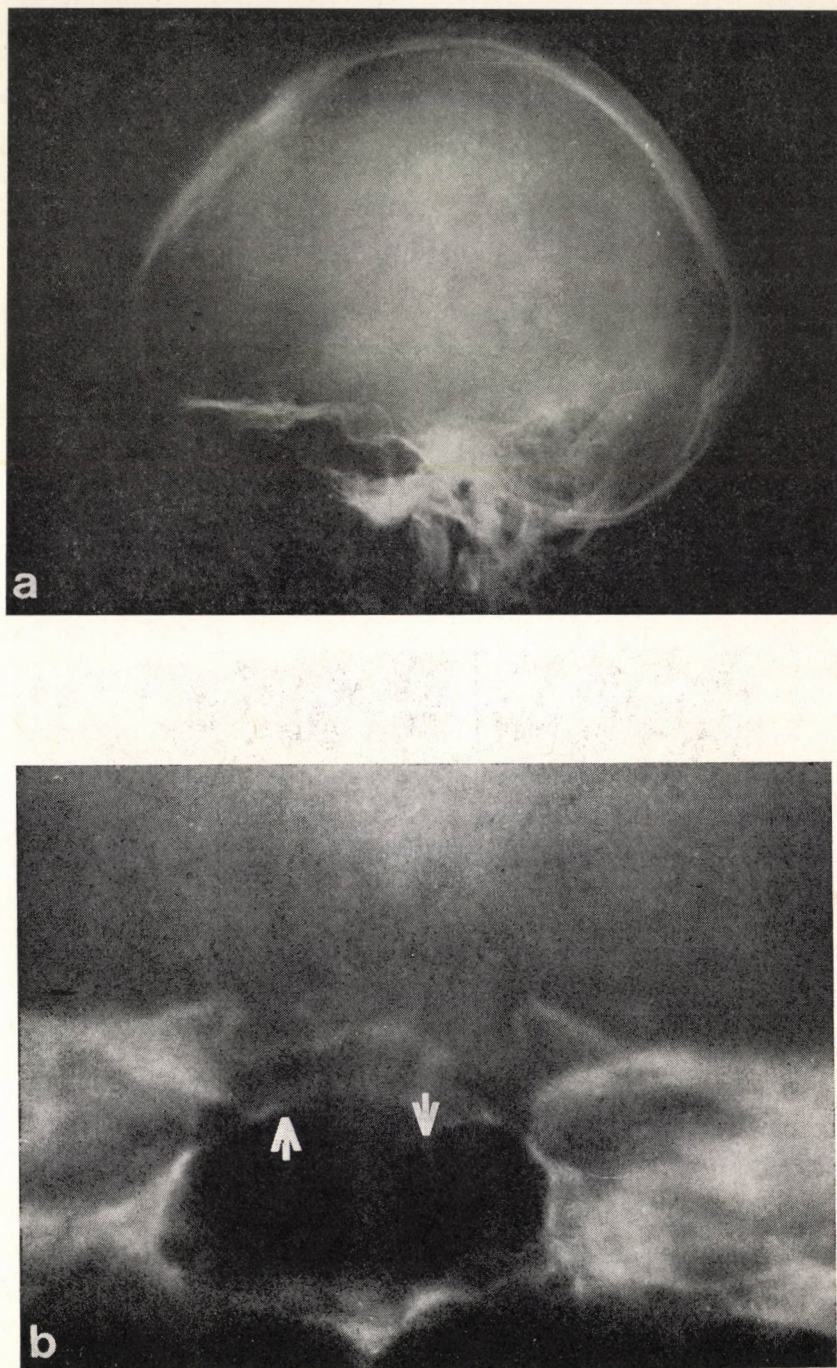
Lateral skull X-ray and frontal tomogram of the sella of patient 6. *a* The lateral film shows a sella of normal size. *b* Sloping sign on the frontal tomogram
